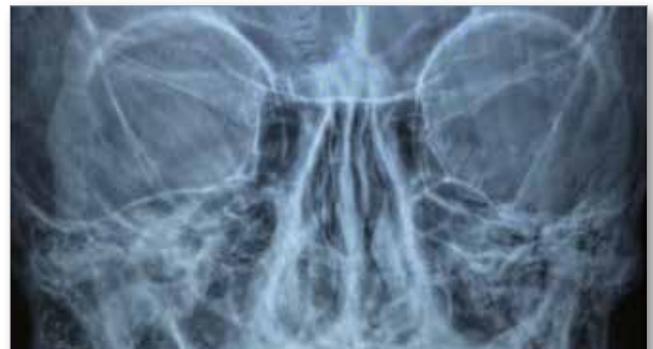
CT scan of the orbit in the frontal projection showing a hyperdense (hyperechoic) foreign body within the right orbital cavity.
